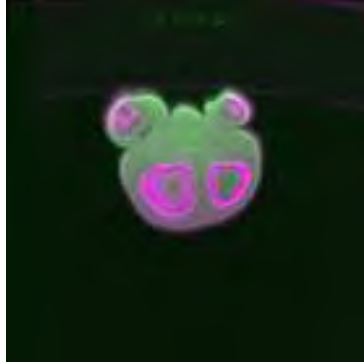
Result of the 3D registration process for ZTE and CT image for one slice.
